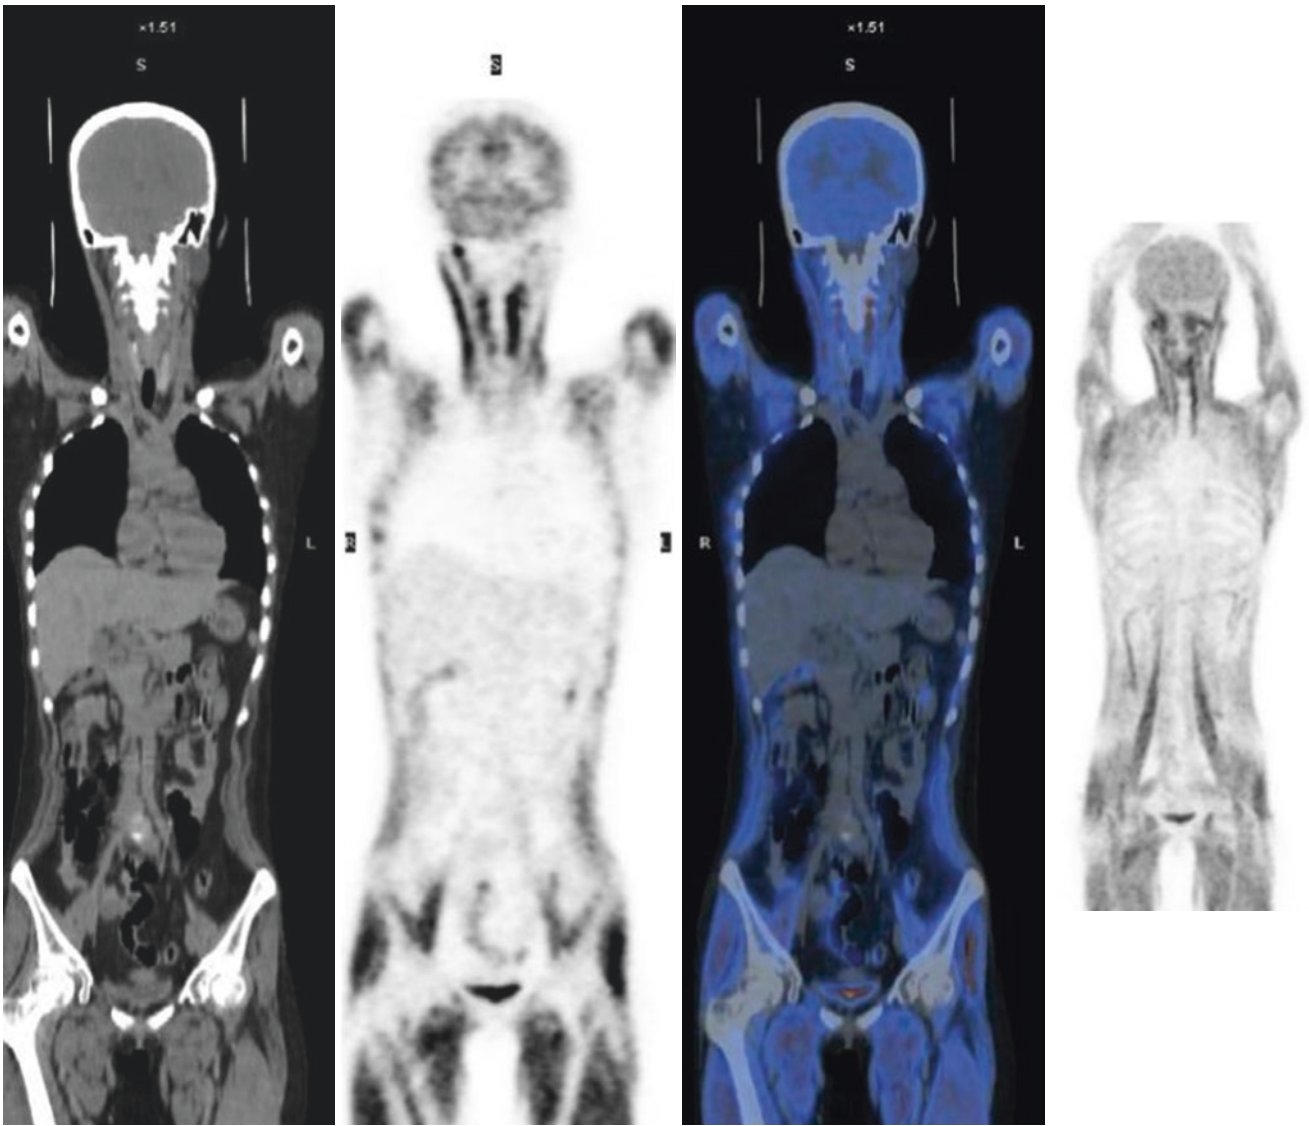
^{18}F -FDG PET/CT image
